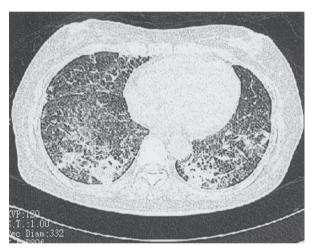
Chest HRCT showing diffuse alveolar densities and interstitial changes in both lower lungs.
